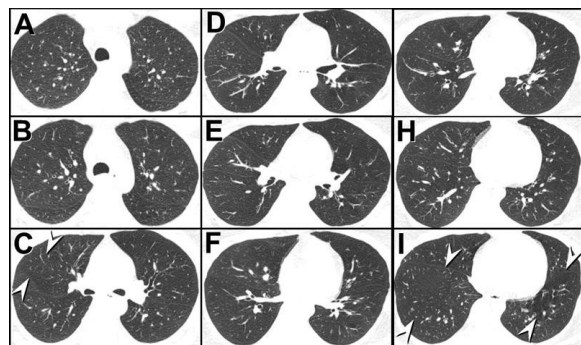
Axial unenhanced post-expiratory HRCT images through the upper (A-C), mid (D-F) and lower (G-I) lungs. Click [here](#) to view Figure 7 in a separate, enlarged window. Click [here](#) to view a video of Figure 7.
